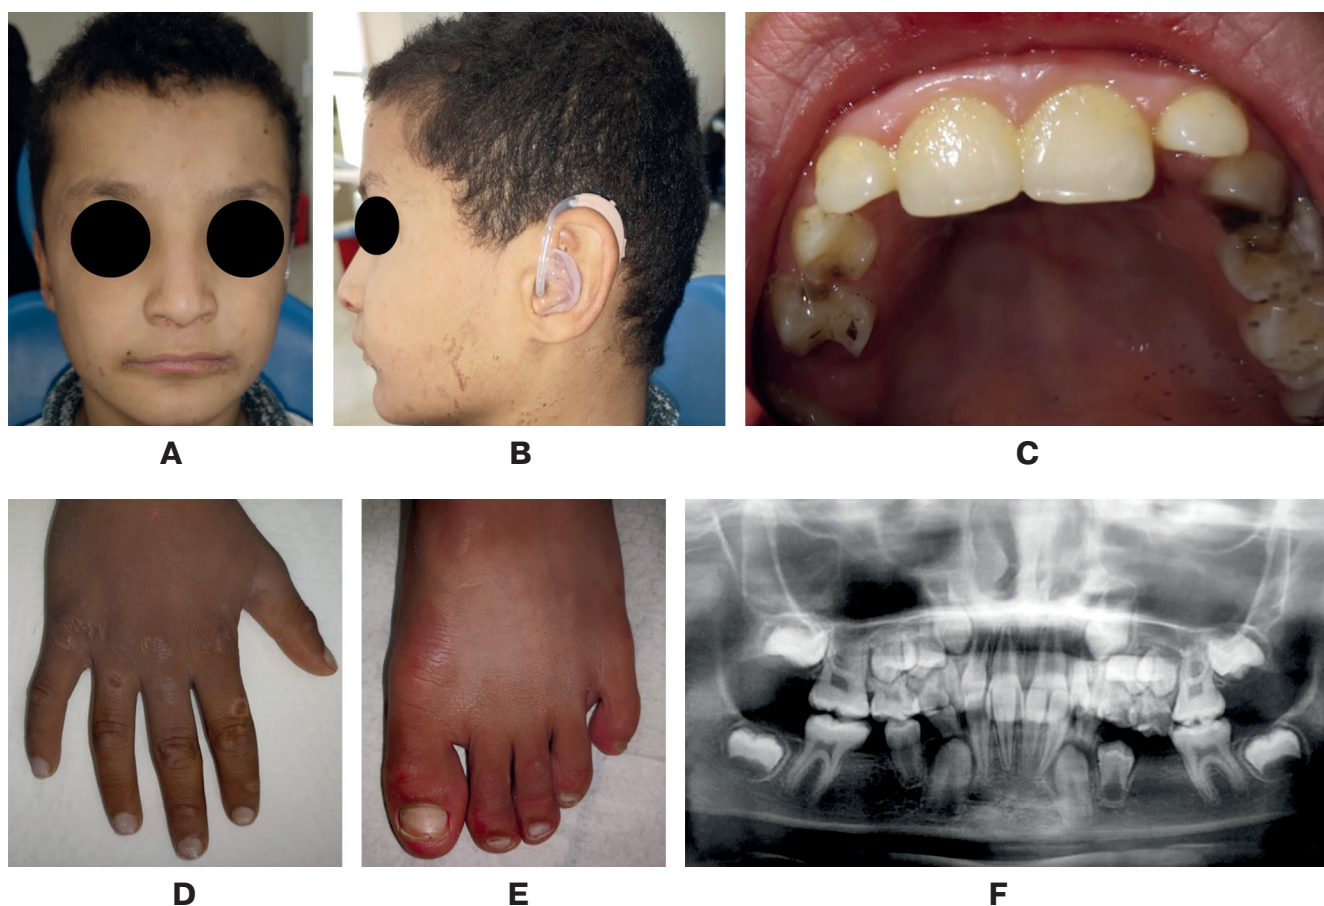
Case 3: A – frontal craniofacial image showing perioral erosions and scarring; B – lateral craniofacial image displaying a hearing aid, indicative of bilateral sensory hearing loss; C – intraoral image showing enamel defects and dental plaque accumulation; D – hand image displaying scarring and nail dystrophy; E – foot image showing hyperkeratotic lesions suggestive of friction-induced blistering; F – panoramic radiograph demonstrating the absence of teeth numbered 35 and 45, likely due to severe dental caries
